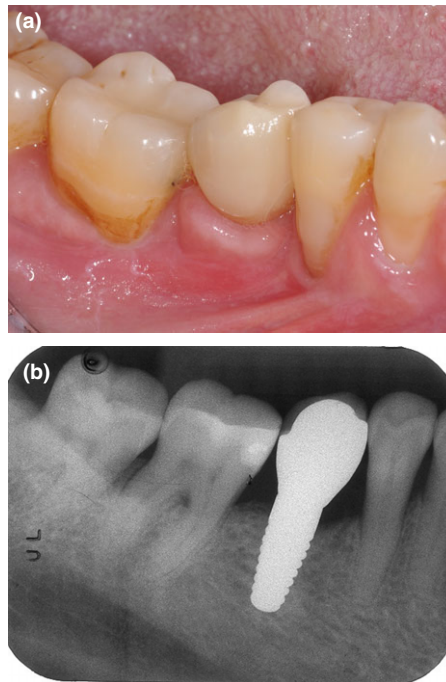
(a, b) Photograph and radiograph at loading.
